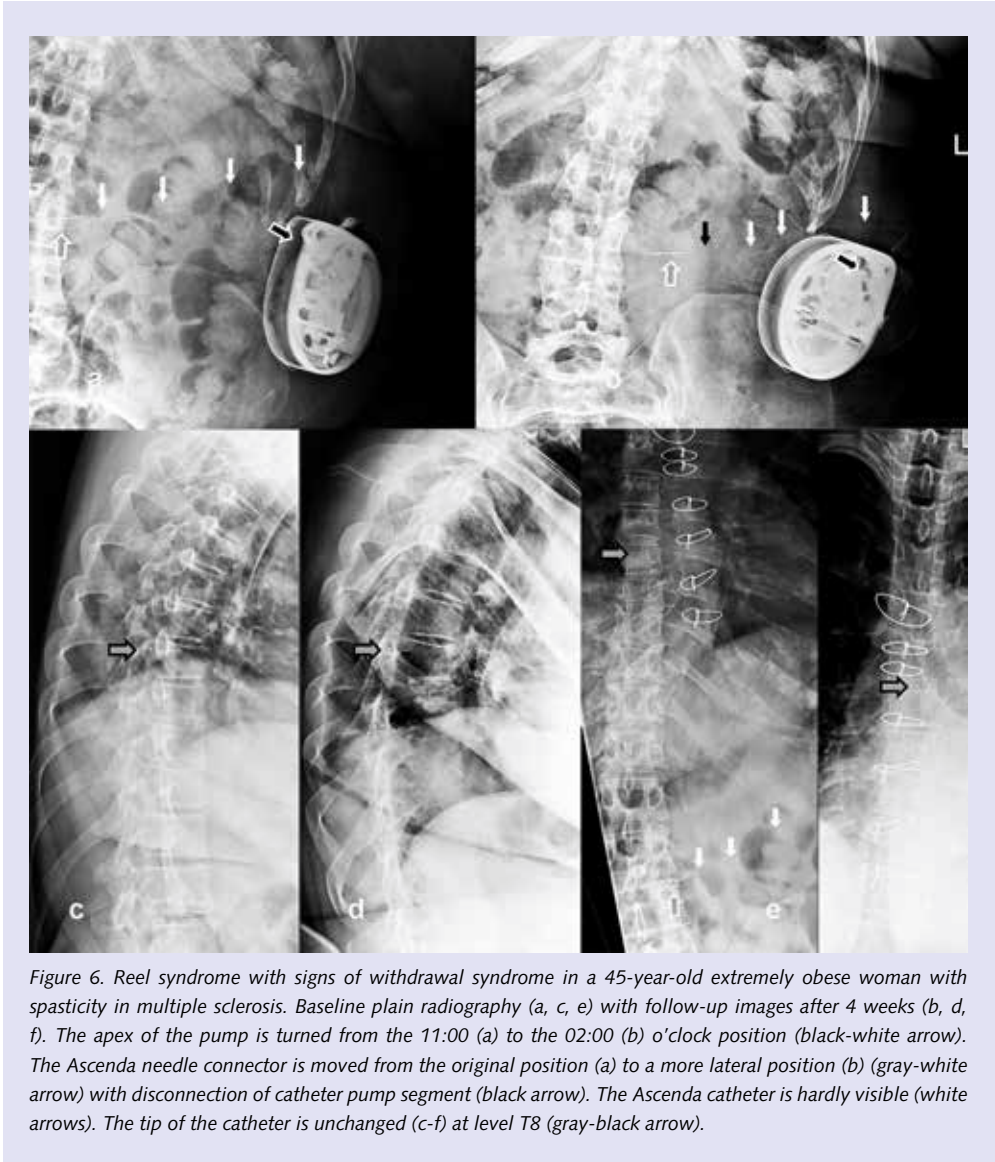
Reel syndrome with signs of withdrawal syndrome in a 45-year-old extremely obese woman with spasticity in multiple sclerosis. Baseline plain radiography (a, c, e) with follow-up images after 4 weeks (b, d, f). The apex of the pump is turned from the 11:00 (a) to the 02:00 (b) o'clock position (black-white arrow). The Ascenda needle connector is moved from the original position (a) to a more lateral position (b) (gray-white arrow) with disconnection of catheter pump segment (black arrow). The Ascenda catheter is hardly visible (white arrows). The tip of the catheter is unchanged (c-f) at level T8 (gray-black arrow).
